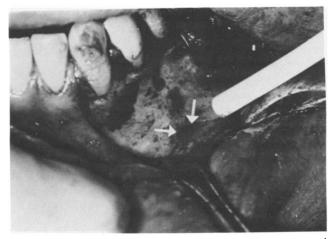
Mental foramen and its neurovascular content (arrows) carefully exposed during periapical surgery.
